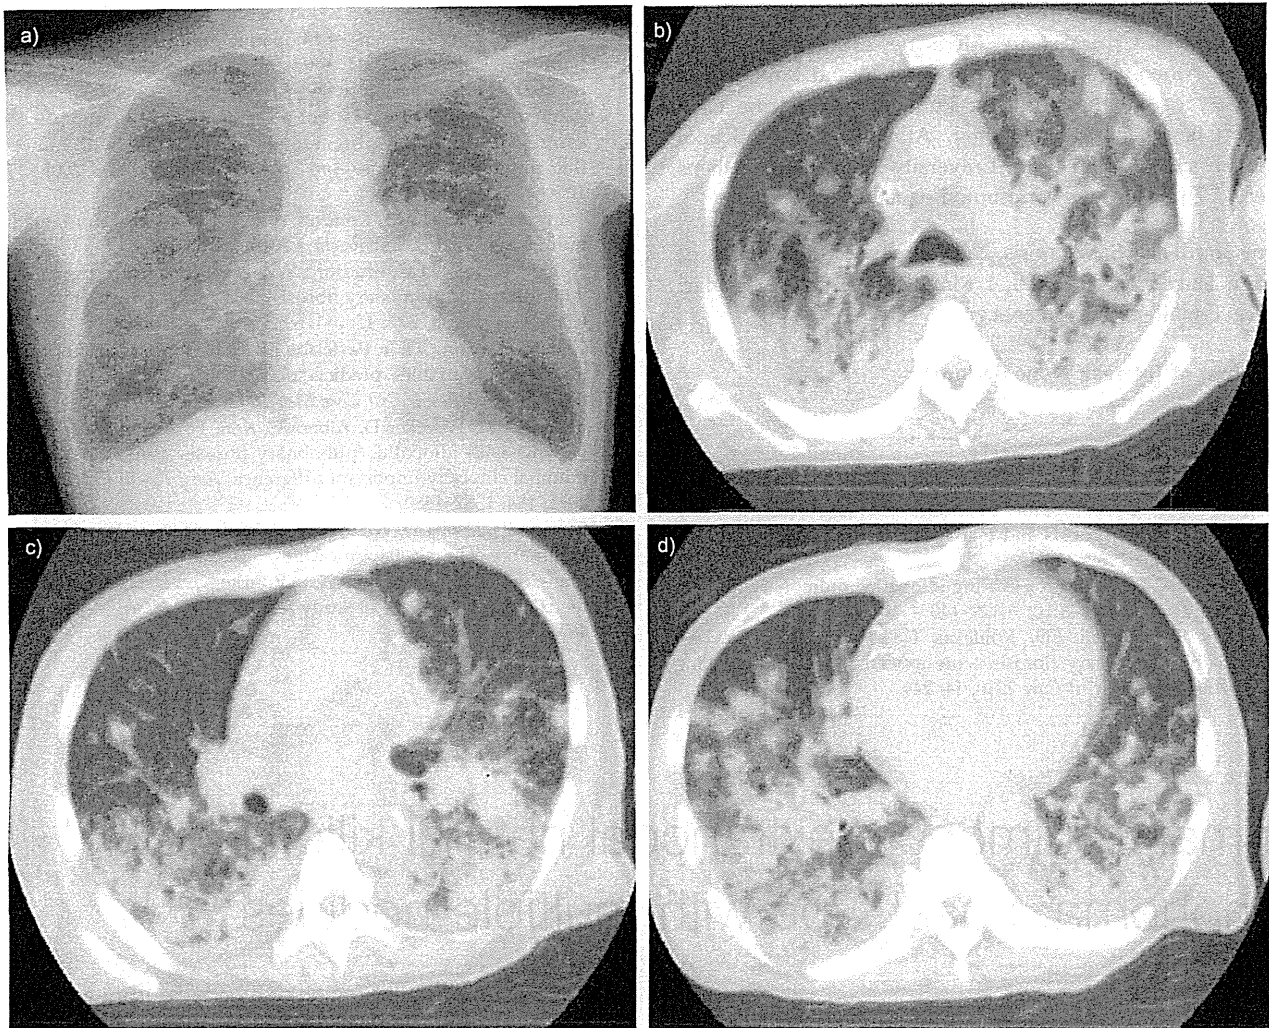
a) Chest radiograph, and b) upper, c) middle and d) lower computed tomography images on admission showing bilateral nodules in both lung fields.
